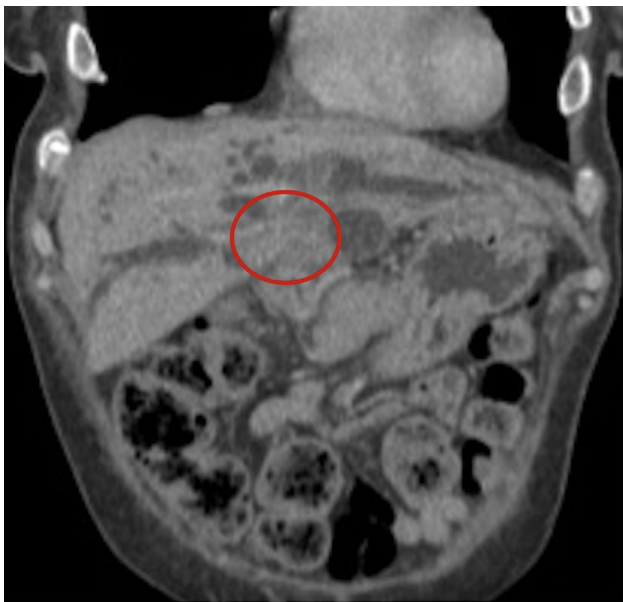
CT coronal scan demonstrating hilar tumor (red circle area) with dilation of bilateral intrahepatic ducts.
